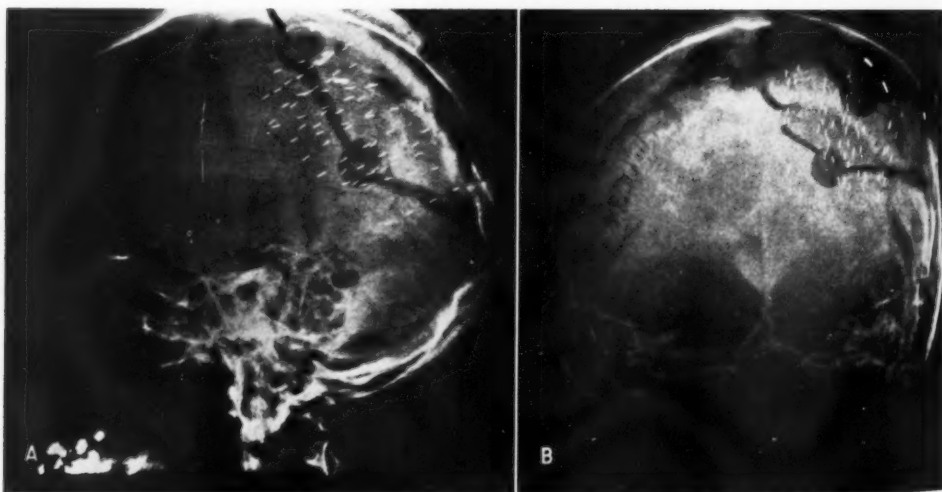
Post-implantation roentgenograms showing the placement of iridium 192 in a 45-year-old man with recurrent glioblastoma multiforme in the right (non-dominant) parietal region. The implantation was carried out ten days after partial surgical resection of recurrent tumor, two hundred and forty-four days after the first wide surgical resection, which had been followed by x-ray therapy (4,000 r in twenty-eight days) and had resulted in several months of complete remission. Following interstitial irradiation (calculated dose of 6,000 r), improvement was evidenced by a partial return of neurological function; but eventual recurrence and death occurred two hundred and fifty-one days after the implantation. Postmortem examination showed that the tumor had widely invaded the brain stem and other mid-line structures beyond the limits of the implantation.
